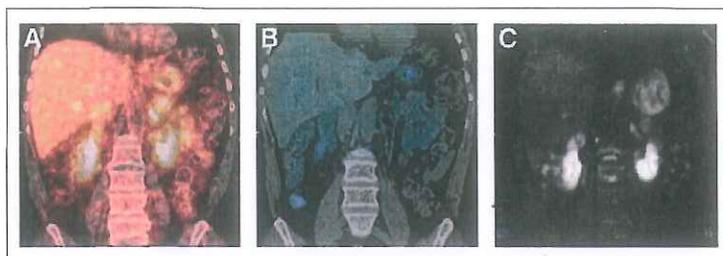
A 61-y-old woman with ileum NET. ^{68}Ga -DOTATATE PET/CT (A) easily identified subcentimeter hepatic metastases, whereas SSRS SPECT/CT (B) and WB DWI (C) did not detect these lesions.
